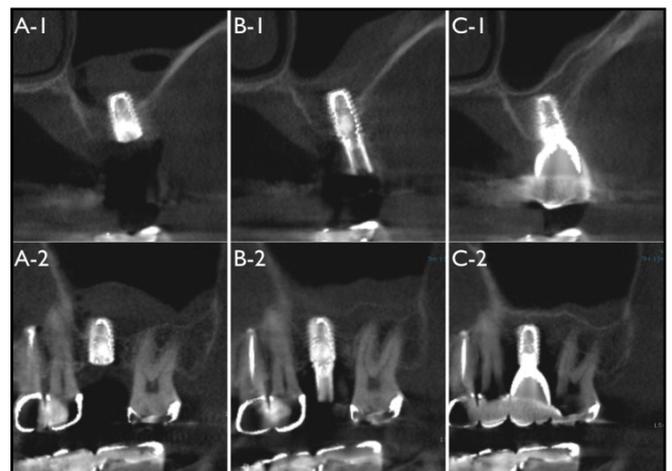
and 4 show panoramic radiographs and CTs, respectively, which were obtained before and after the insertion of the implant. Immediately after surgery, the Schneiderian membrane was elevated in a dome shape (Figures 3B, 4A-1, 4A-2). At three-months after surgery, the elevation of the membrane had decreased, however, it was still positioned above the implant tip (Figure 3C). At six months after surgery, the position of the elevated membrane remained above the implant tip and was stable (Figures 3D, 4D-1, 4D-2). At twelve months after surgery, newly-formed mineralized tissue was clearly visible (Figure 3E). At eighteen months after the surgery, the new sinus floor line was stable above the implant tip and was becoming obvious (Figures 3F, 4C-1, 4C-2). The new sinus floor was above the implant tip and the cortical outline was clear.
